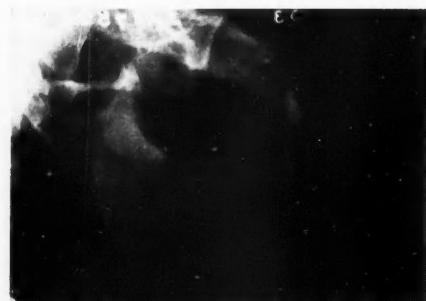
Post-operative right lateral oblique radiograph showing window in bone and dilatation of inferior alveolar canal with root removed.
